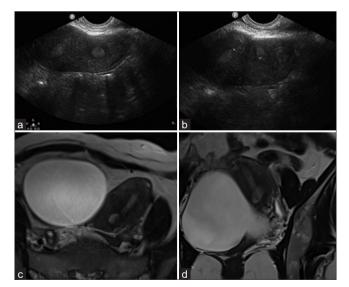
(a and b) Transabdominal USG showing separation of endometrial cavities in the fundal region of uterus. (c and d) T2-weighted axial image (2C) showing separation of endometrial cavities in the fundal region with no dip in the external uterine. T2-weighted coronal image (2D) showing separation of endometrial cavities in the fundal region with angle ~ 70° indicating septate uterus
